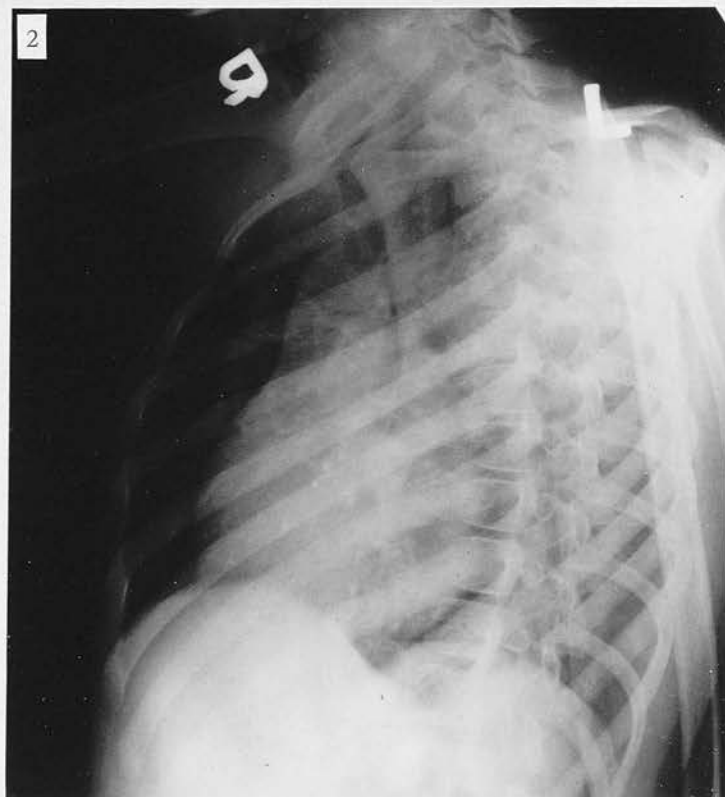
Radiograph of Case 23. Slight cardiac enlargement with unusual degree of R.V. enlargement in school child.
